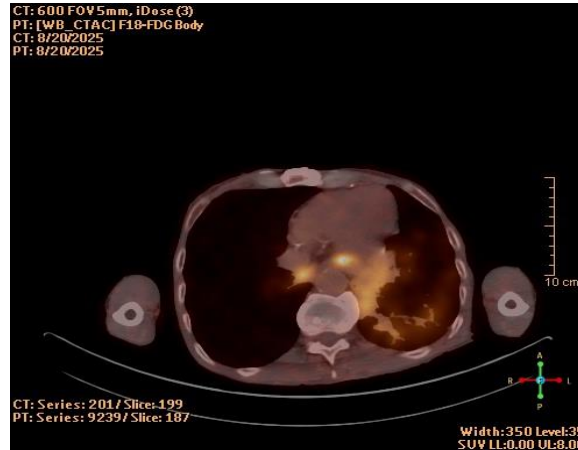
Examples of CT and PET application in navigation
